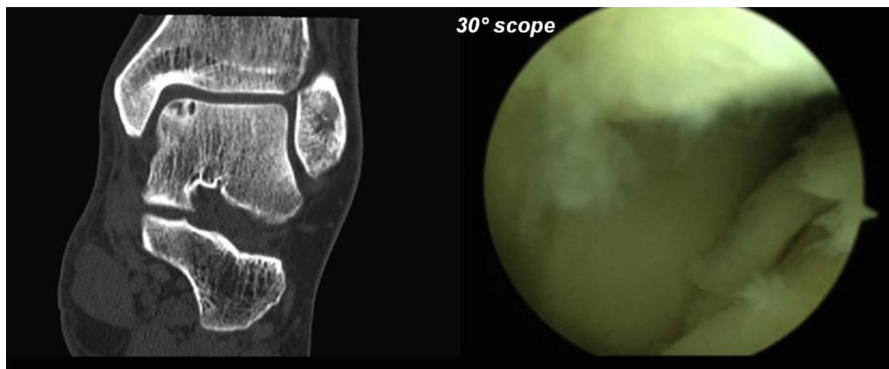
Uncontained OCD involving the medial talar shoulder in a left ankle. A computed tomography scan, coronal image, is shown on the left. Arthroscopic view through the anterolateral portal is shown on the right. The area of the lesion localized over the medial talar shoulder is hardly seen with the 30° arthroscope placed in the anterior portal contralateral to the lesion.
